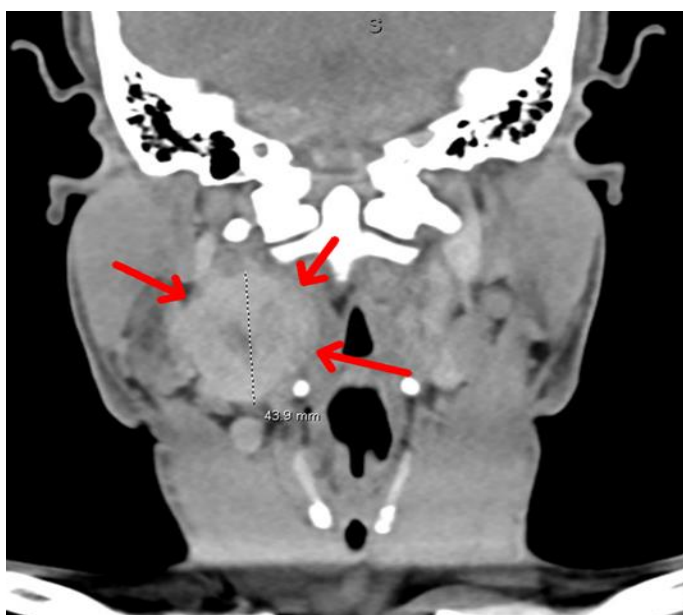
Coronal CT imaging revealing right-sided 3.9 x 4.4 x 4.9 cm carotid body paraganglioma (red arrows) with lymphadenopathy and mass effect on surrounding structures.
